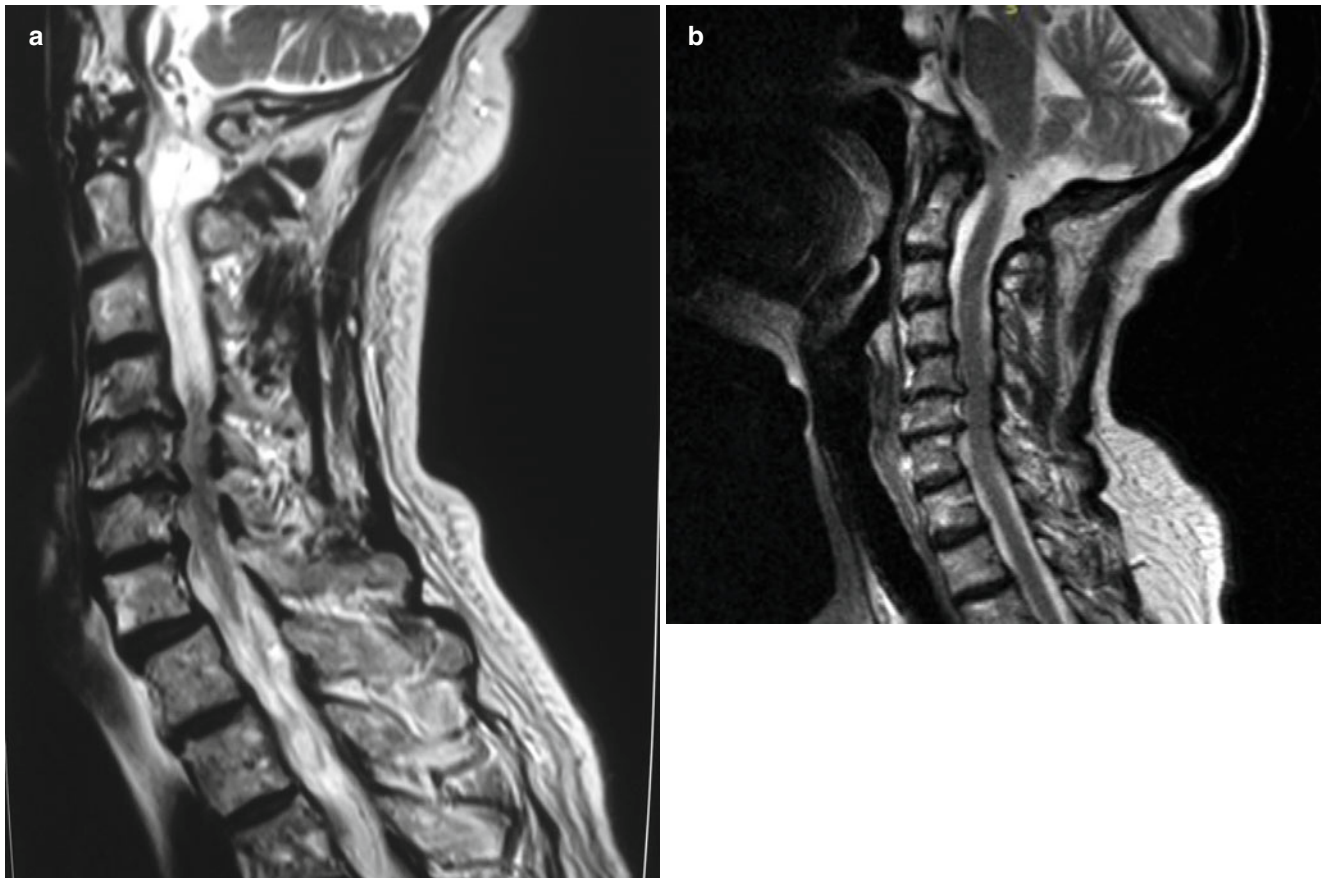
(a, b) MRI (sagittal plane) of the cervical spine showing multiple disc herniations and osteophytes
